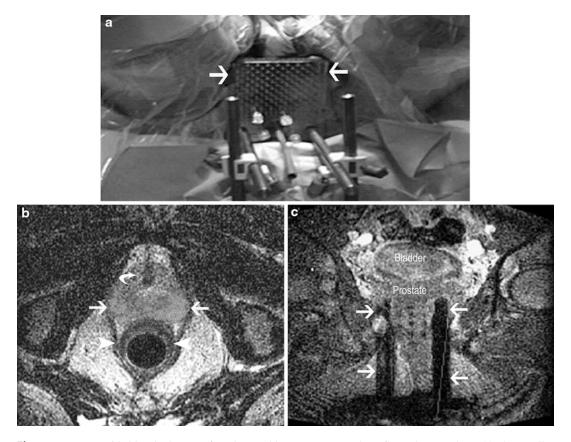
MRI-guided brachytherapy of a 75-year-old man with prostate cancer. The template (*arrows* in a) is placed against the patient's perineum and secured to the MRI scanner table. Axial T2-weighted MR image (b) obtained and using special software a radiologist marked the peripheral zone of the prostate gland (*arrows*), urethra (*curved arrow*), and rectal wall (*arrowheads*). With designated planning software, a medical physicist generated
